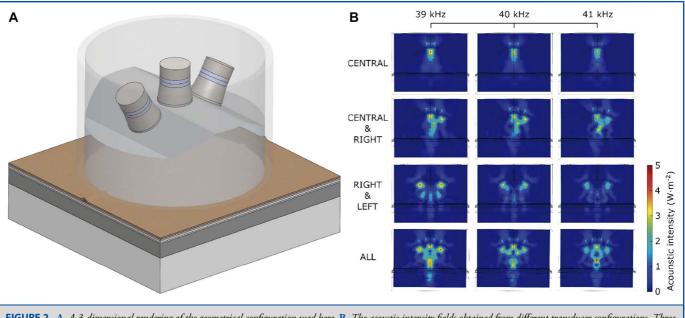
A, A 3-dimensional rendering of the geometrical configuration used here. B, The acoustic intensity fields obtained from different transducer configurations. Three different ultrasound frequencies were used. The transducers were position with their radiation axis in a 30° angle configuration relative to the vertical line. A high-intensity node was induced when all transducers were activated at 41 kHz. The amplitude of the emitters was set to 1 MN m^{-3} .
